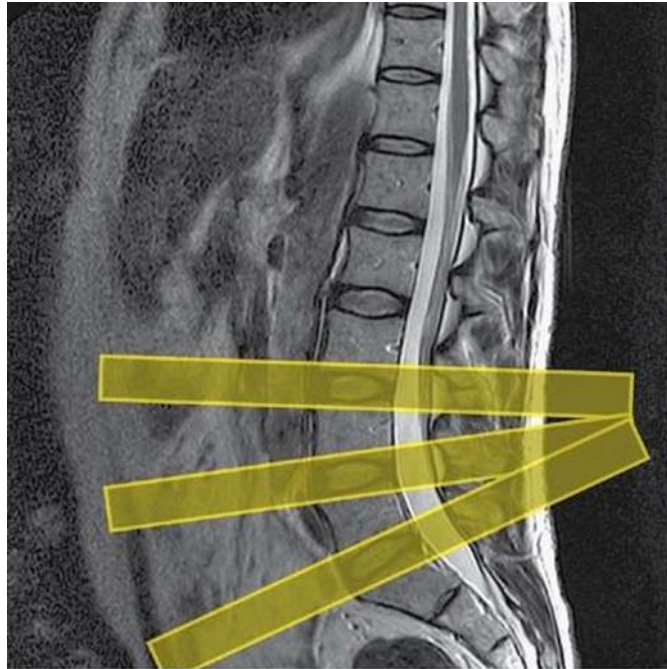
Sagittal FSE T2-weighted midline slice showing slice prescription boundaries and orientation for axial/oblique imaging of lumbar discs. (Westbrook, 2014)
